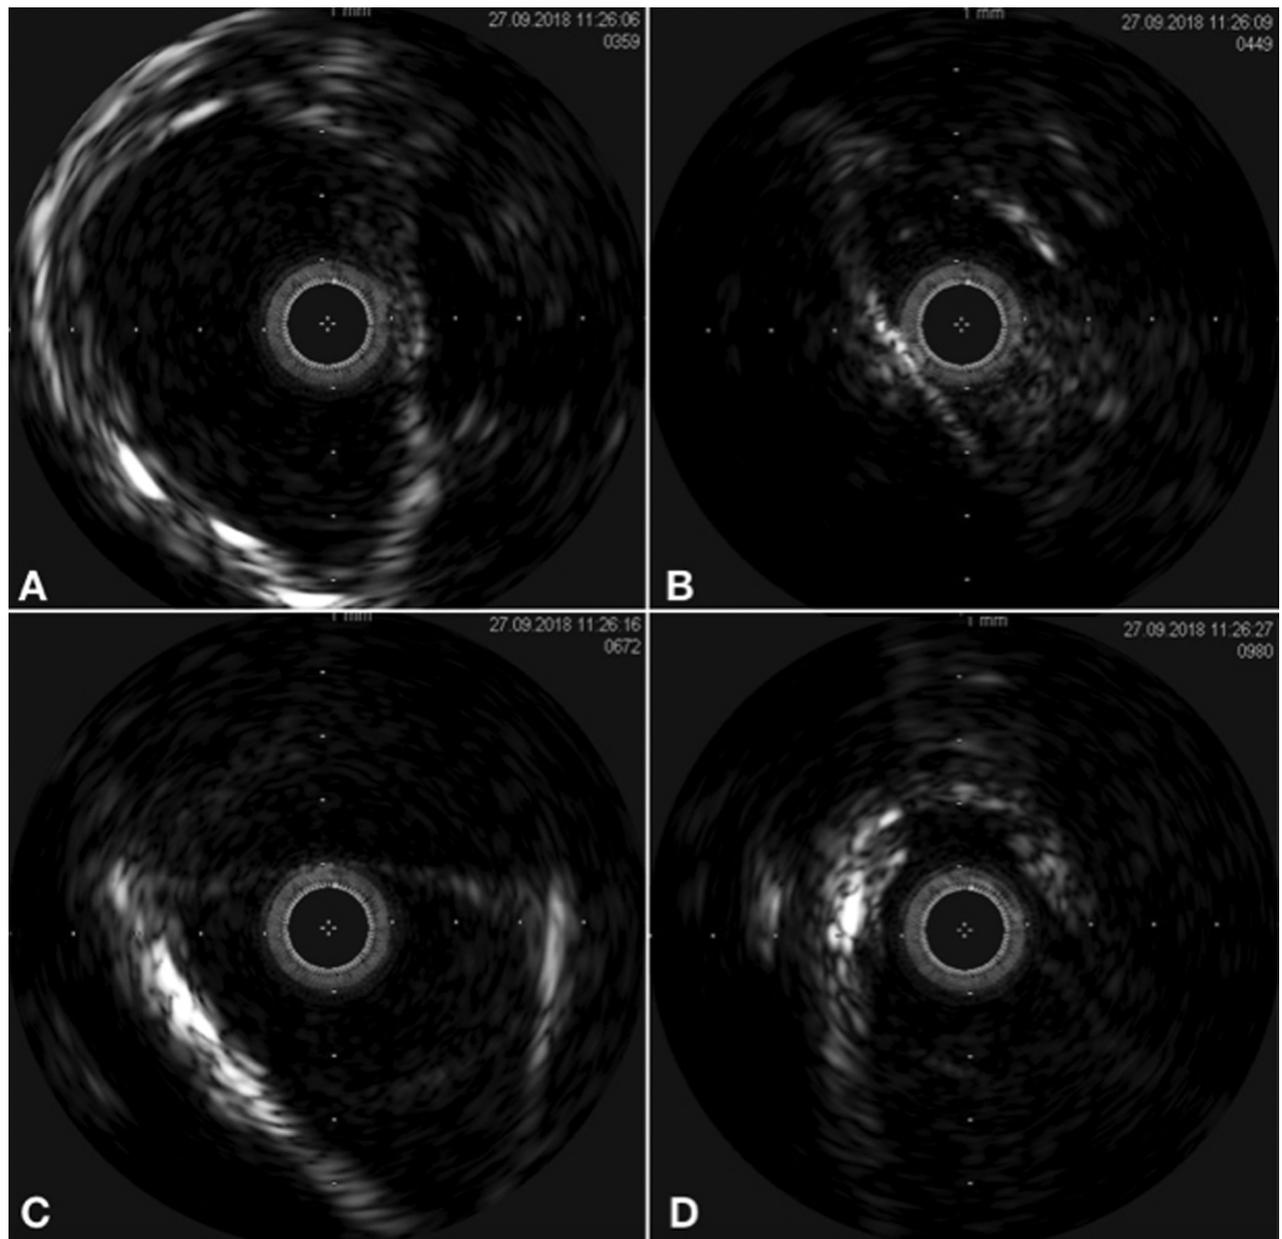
Images of intravenous ultrasound. Poststenosis left transverse sinus (A). Interior of left transverse sinus stenosis (B). Prestenosis right transverse sinus (C). Interior of right transverse sinus stenosis (D).
